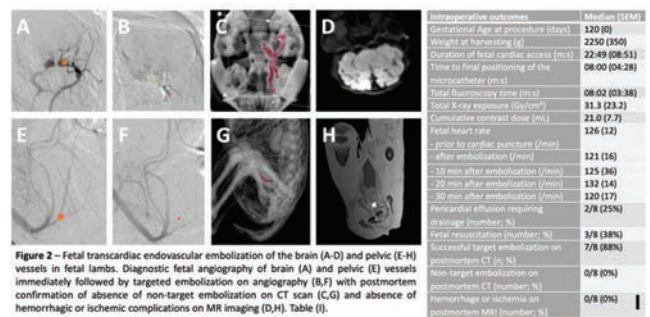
Fetal transcatheter endovascular embolization of the brain (A-D) and pelvic (E-H) vessels in fetal lambs. Diagnostic fetal angiography of brain (A) and pelvic (E) vessels immediately followed by targeted embolization on angiography (B,F) with postmortem confirmation of absence of non-target embolization on CT scan (C,G) and absence of hemorrhagic or ischemic complications on MR imaging (D,H). Table (I).
